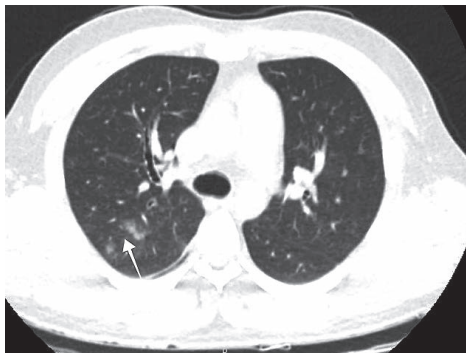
Patient 2: Chest computed tomography on admission. Mild ground-glass opacities are observed (white arrow). The patient had no supplementary oxygen requirement. Ct (cycle threshold) was 28.
